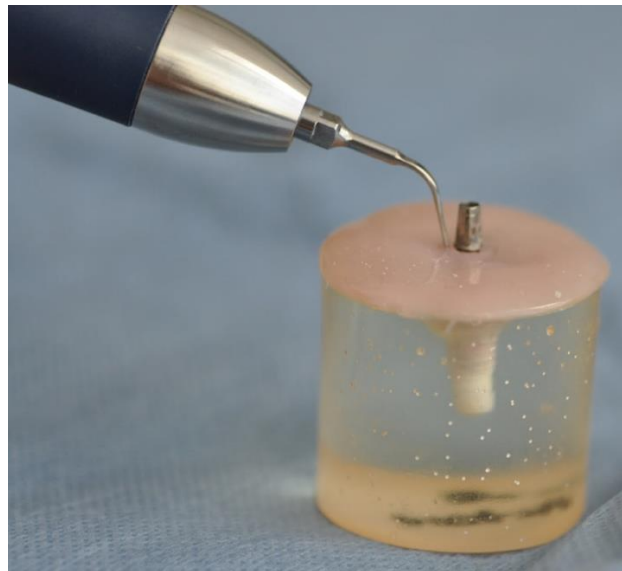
The ultrasonic scaler (VUS) device
